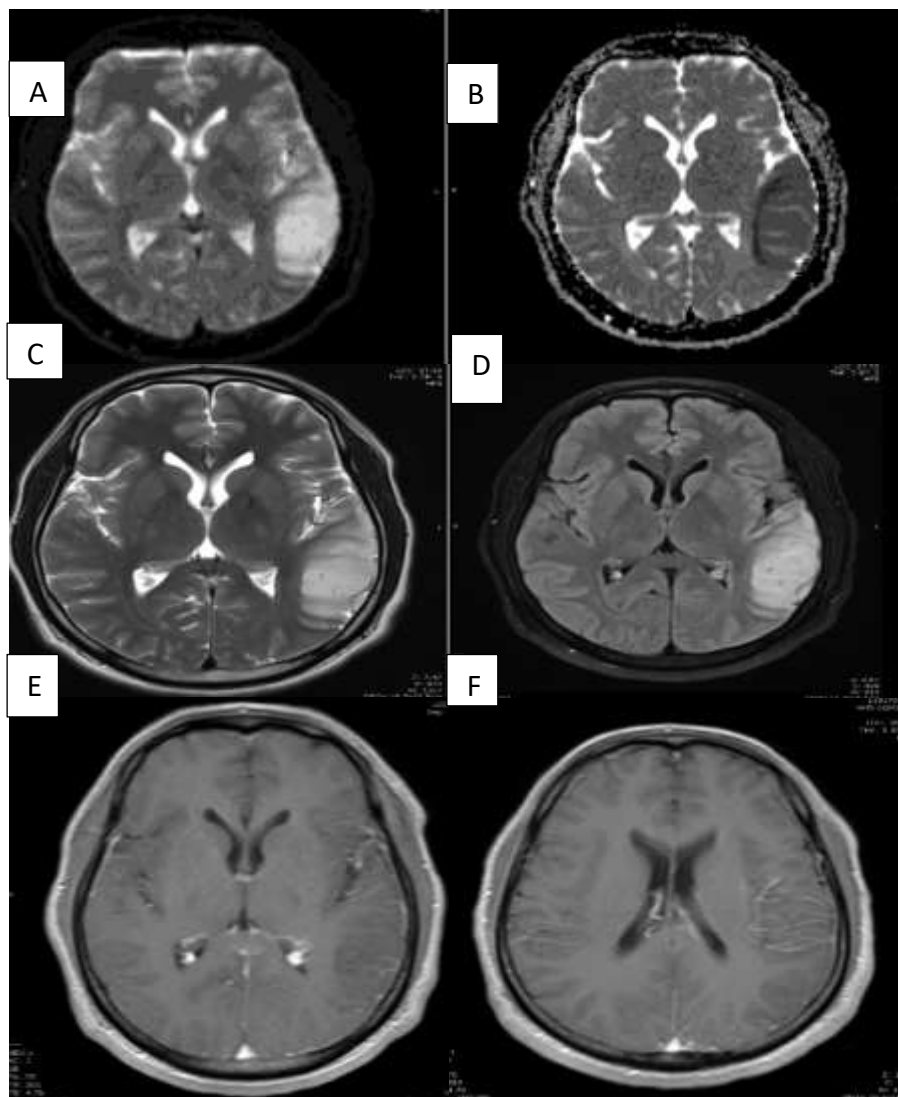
Encephalitis: MRI, DWI, ADC, T2 WI, FLAIR and T1 post contrast. shows left temporoparietal cortex including the operculum and the posterior insular cortex, posteriorly extending up to the posterior arterial border zone. Interestingly this region shows features of hyperperfusion in the CT perfusion scan done earlier on the same day; and also this MRI shows increased size of the left MCA branches supplying this region. No definite slow flow collaterals are seen in the FLAIR sequence or SWI.
